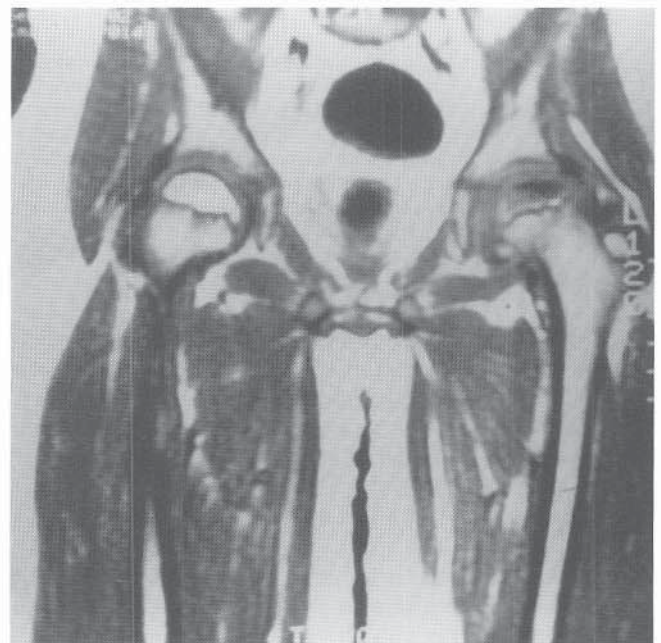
MRI of a 9-year-old boy with Legg-Calvé-Perthes disease showing extensive involvement of the left hip.
